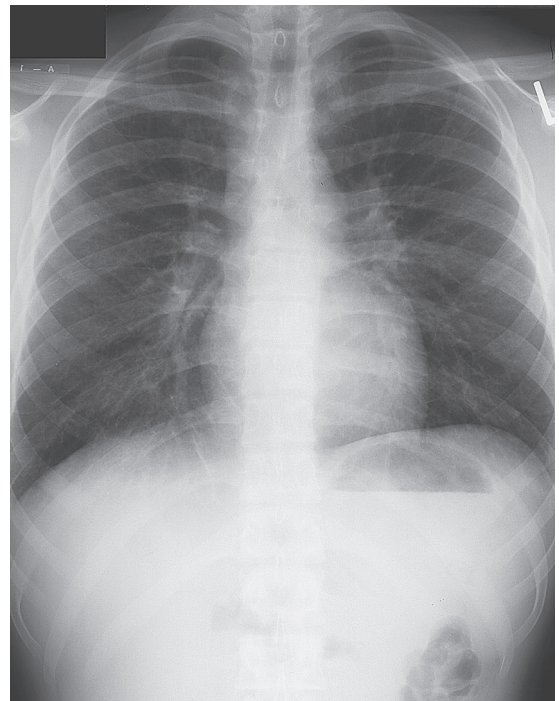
■ Posteroanterior chest radiograph demonstrating a fine interstitial pattern indicative of *Mycoplasma pneumoniae*.
